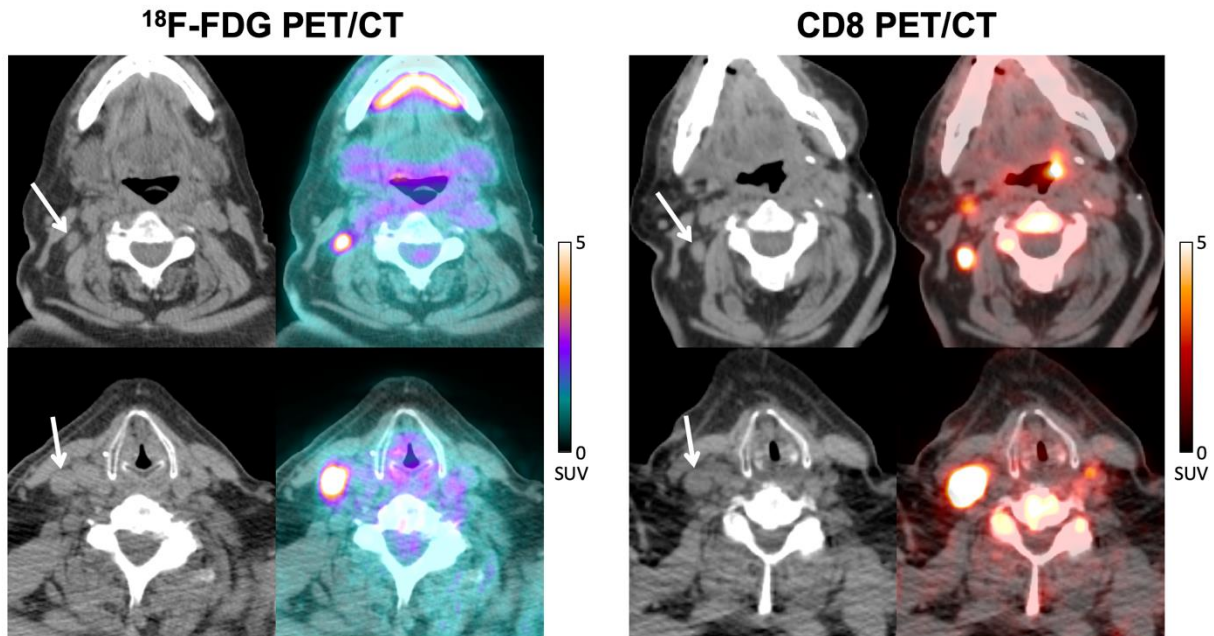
77-year-old man with metastatic melanoma treated with pembrolizumab. CT and fused FDG PET/CT images (left) acquired at ~8 months post initiation of immunotherapy demonstrate two FDG avid nodal metastases in the right neck ($SUV_{MAX} = 8.0$, top image; $SUV_{MAX} = 16.8$, bottom image), which could represent viable metastases. Corresponding CT and fused CD8 PET/CT images (right) performed 1 month after the FDG PET/CT demonstrate significant tracer activity in both metastases ($SUV_{MAX} = 5.4$, top image; $SUV_{MAX} = 14.6$, bottom image), which suggests that some of the FDG activity could be due to tumor-infiltrating CD8+ T cells rather than tumor cells. Follow-up imaging over the next 6 months demonstrated stable disease, supportive of this hypothesis.
